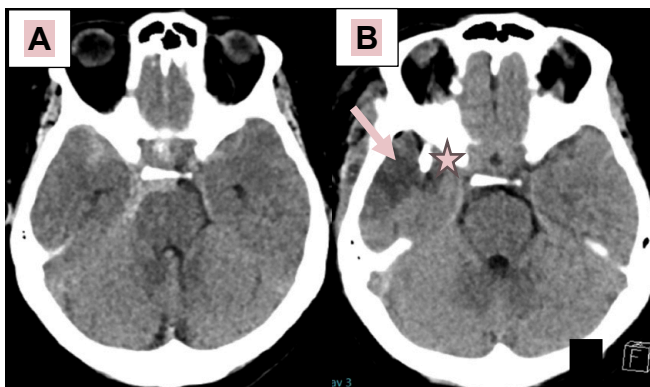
CT scan before (A) and after (B) clipping of a ruptured MCA aneurysm. In (B) the arrow is pointing at an infarction caused by adjacent vessel injury and the star indicates the titanium clip.
